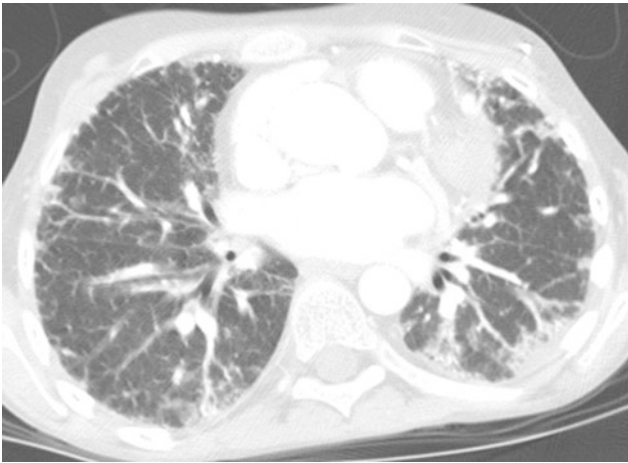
Dyskeratosis congenita (DKC). An axial chest CT image of a 12-year old shows diffuse bilateral linear and patchy pulmonary opacities, predominantly in a subpleural distribution, representing DKC-related pulmonary fibrosis
